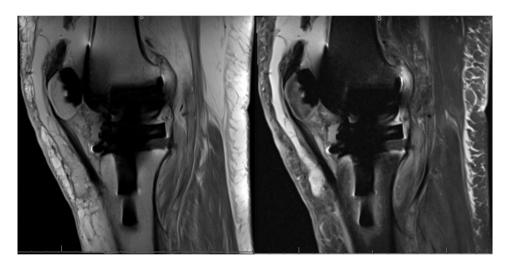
Sagittal MRI sequences demonstrating a quadriceps tendon rupture occurring in the setting of a total knee arthroplasty. MRI, magnetic resonance imaging.
